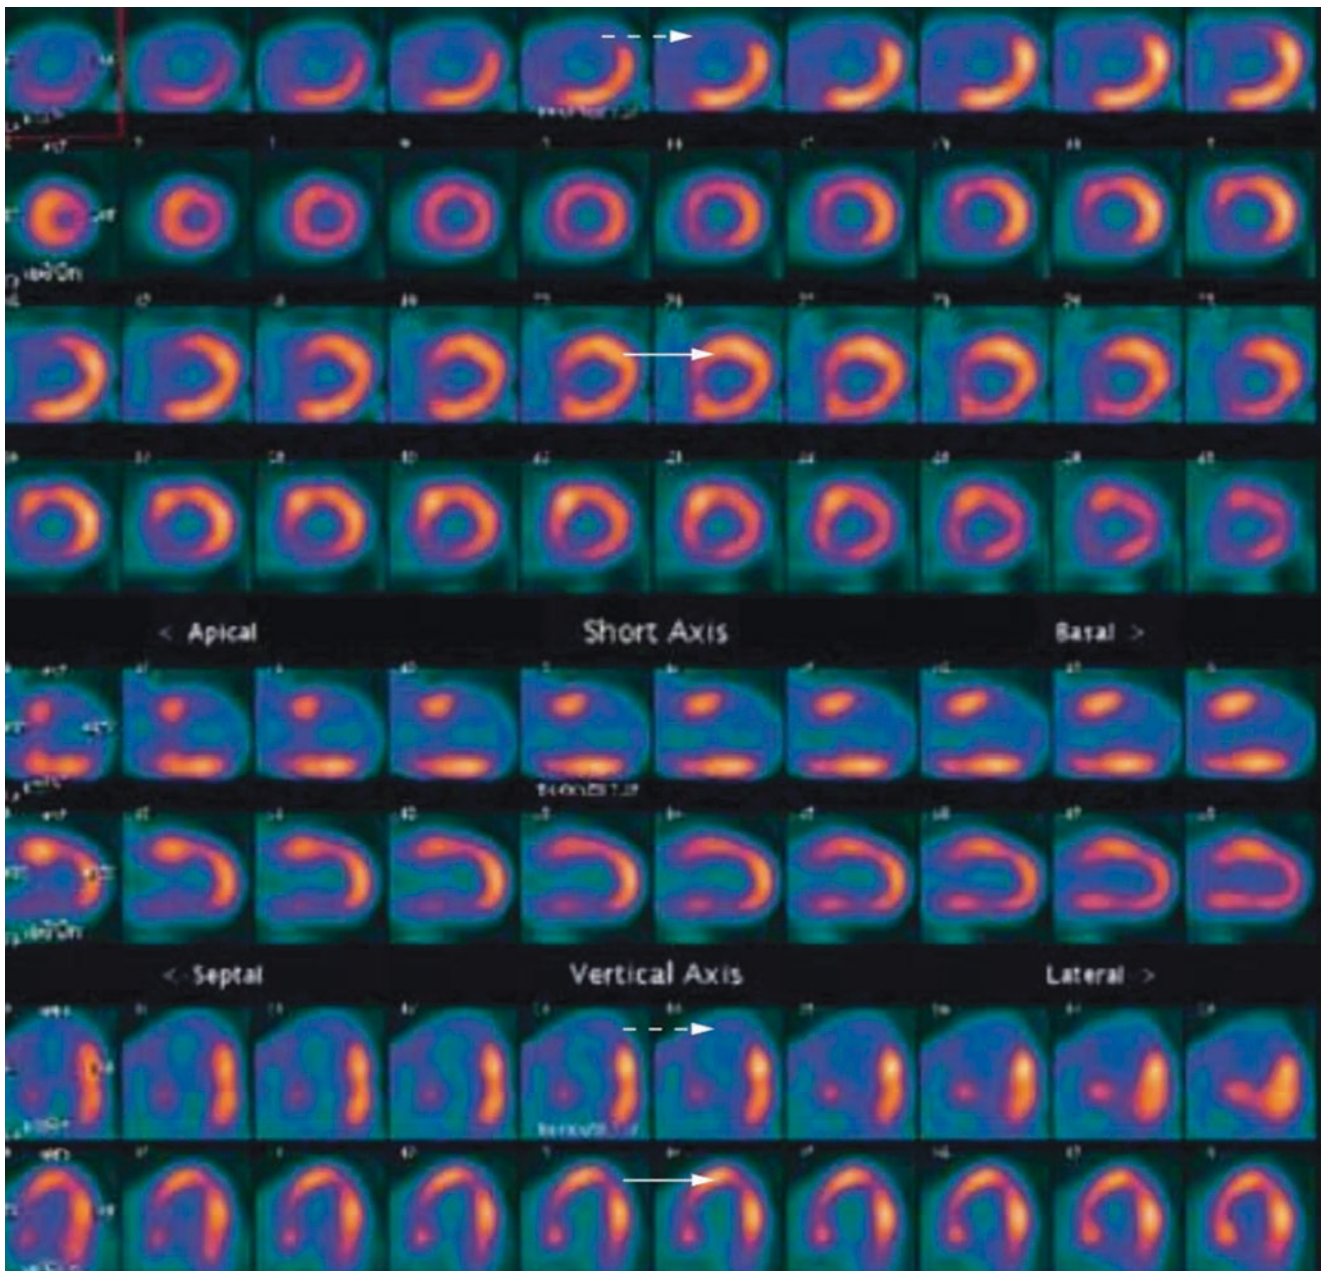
Perfusion defect on ^{82}Rb PET imaging (dashed arrow) shows normal uptake of ^{18}F -FDG demonstrating viable myocardium (solid arrow)
